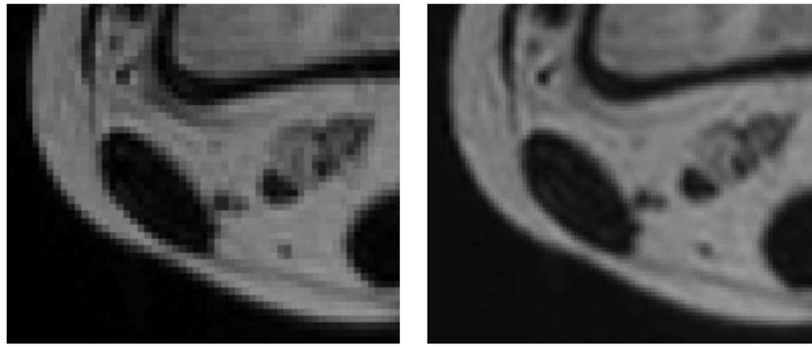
Resampling of an MRI scan of the leg from $0.9 \times 0.9 \times 2.0 \text{ mm}^3$ (left) to $0.5 \times 0.5 \times 0.5 \text{ mm}^3$ (right) by means of the Lanczos interpolation method. Although no additional information has been used to generate the higher-resolution image, some structures appear more clearly.
